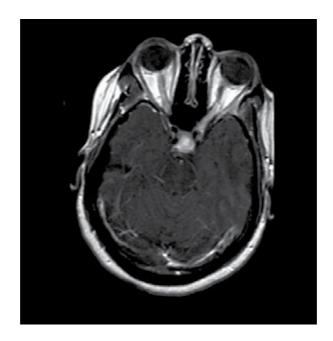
Gadolinium enhanced MRI of the brain demonstrating bilateral optic nerve and pituitary axis enhancement
